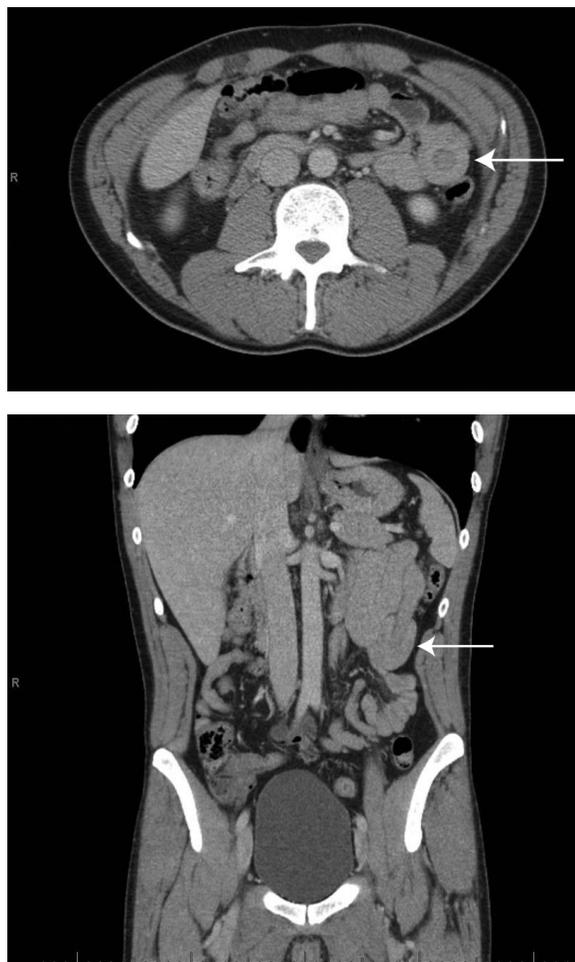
Abdominal computed tomography with intravenous contrast of a 37-year-old man with enteroenteric intussusception. Top: axial view showing the characteristic “target sign” in the left upper quadrant. Bottom: coronal view with jejunum-jejunal intussusception again seen in the left upper quadrant.
